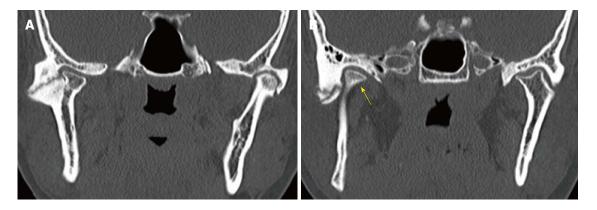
Post traumatic ankylosis in a 28-year-old male patient. Coronal reformatted multi-detector computed tomography images demonstrate ankylosis and pseudo-joint formation in both temporomandibular joints (A); mandibular condyle is displaced anteriorly and medially (B). The referring clinician needs to know the relationship of the condylar mass to adjacent skull base structures.
